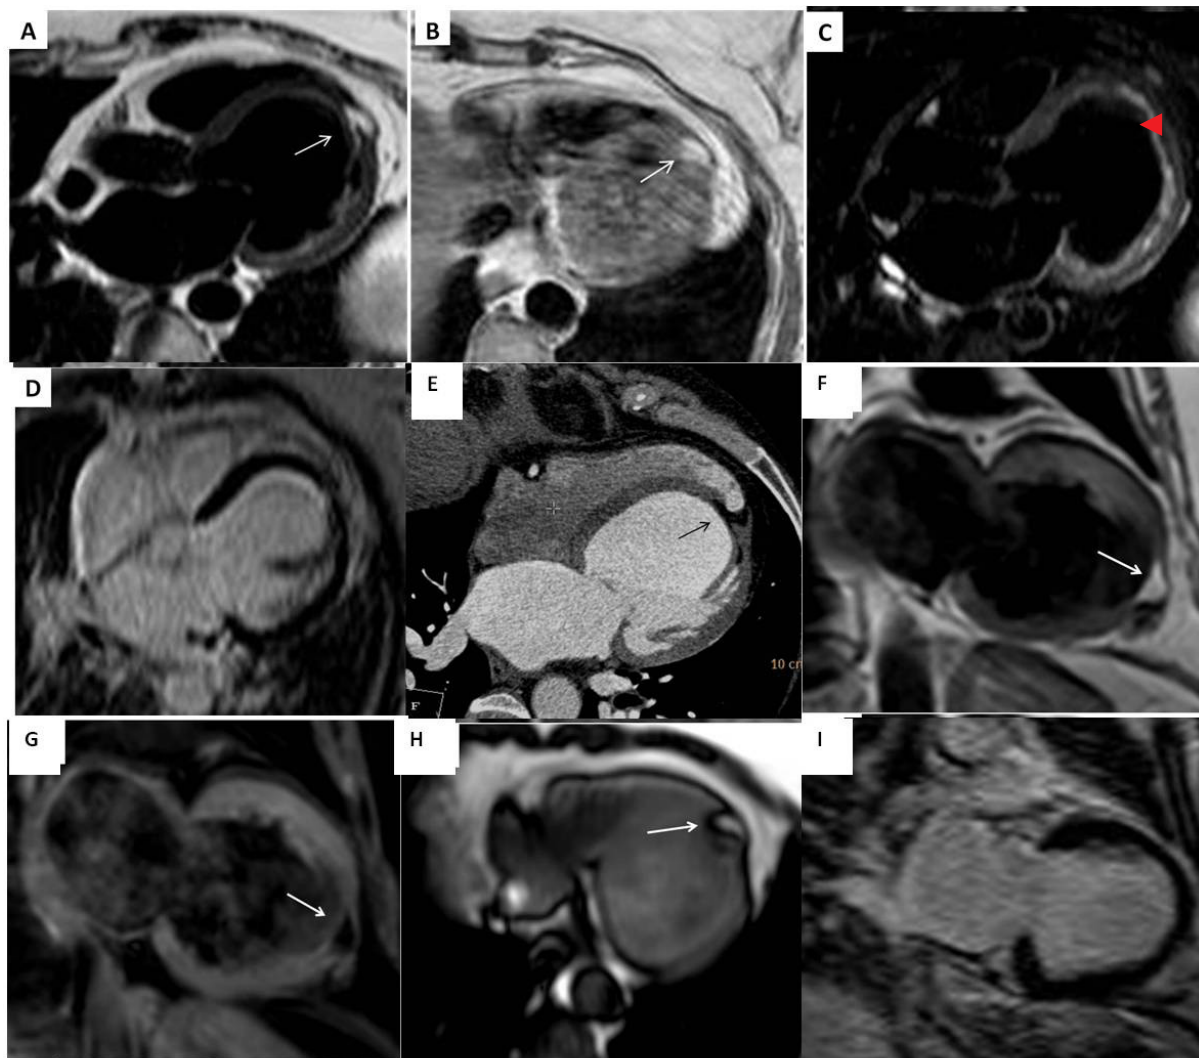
MRI axial images of the heart using different pulse sequences to demonstrate myocardial segment of fatty infiltration in the LV apex. The CMR protocol included T1-weighted spin-echo (with-and-without fat-suppression), T2-weighted black-blood image, and DHE after administration of gadolinium. (A) T2-weighted black blood; (B) T1-weighted turbo spin echo; (C) T1-weighted turbo spin echo with fat saturation (showed clear nulling of apical fatty area); (D) DHE technique showing no evidence of myocardial scar; (E) Multi-detector CT image that shows a focal area of fatty infiltration in the LV apex (black arrow). This area has a negative Hounsfield value indicating its fatty nature. Follow-up 3 Tesla CMR study after 18 months showed no significant changes in fat distribution within LV; (F) Two-chamber T1-weighted turbo spin echo showing the fatty area at the LV apex; (G) Two-chamber T1-weighted turbo spin echo with fat saturation showing clear nulling of apical fatty area; (H) Axial T1-weighted single-shot axial image of the most distal apical portion of LV showing part of the fatty area; (I) DHE technique showing no evidence of myocardial scar; however, the fatty area is not enhanced.
